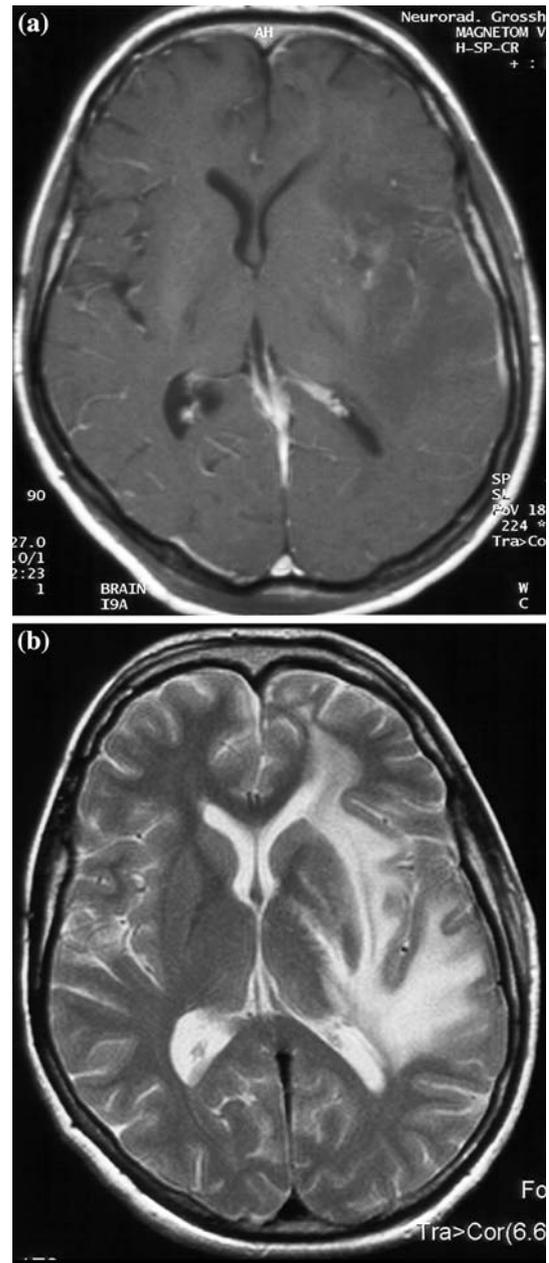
(a) MR prior to initial surgery April 2001; (b) left frontal surgical cavity after tumor removal (October 2002); (c) remote secondary lesion with hemispheric edema (t1 weighted MR with contrast and t2-weighted MRI)
